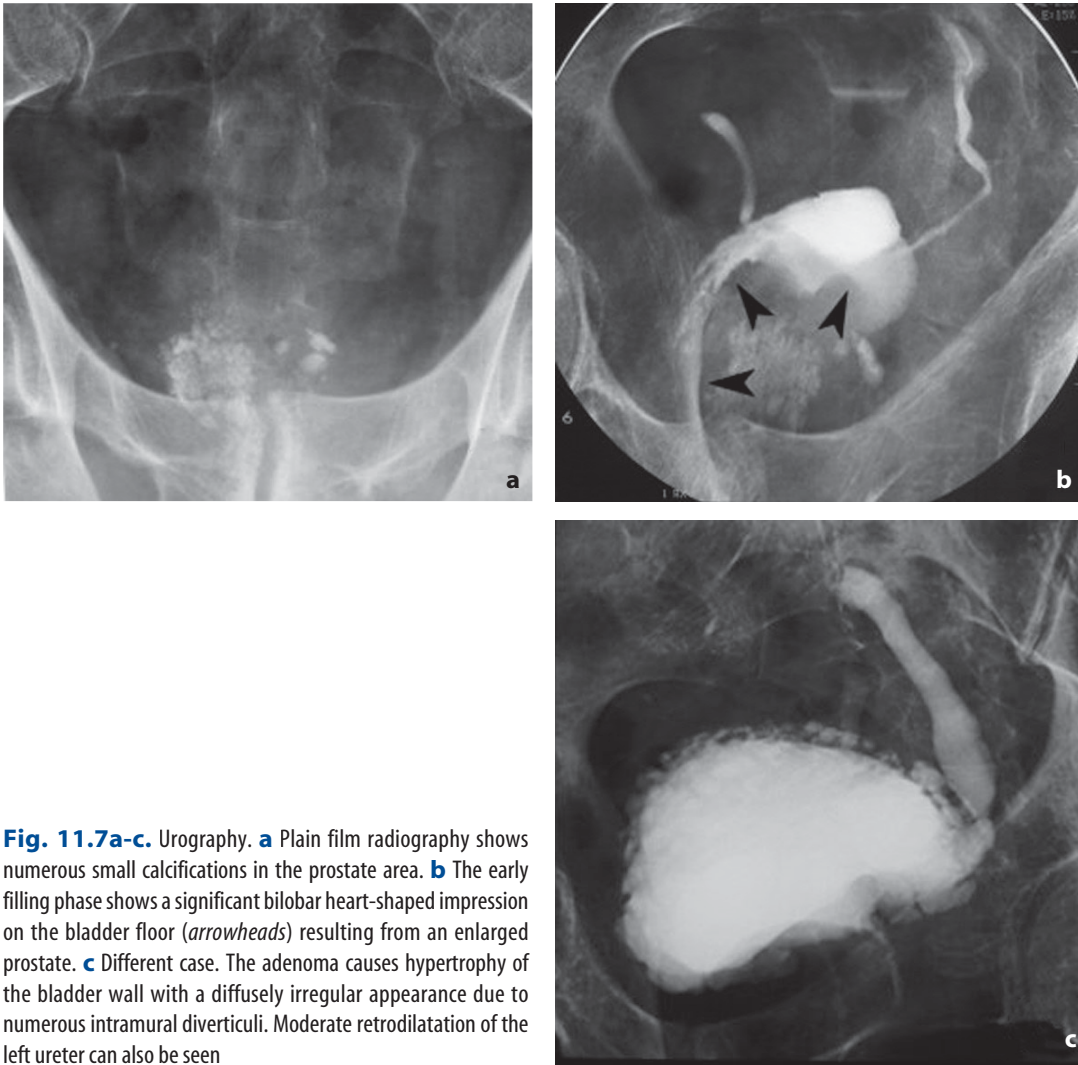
Urography. a Plain film radiography shows numerous small calcifications in the prostate area. b The early filling phase shows a significant bilobar heart-shaped impression on the bladder floor (*arrowheads*) resulting from an enlarged prostate. c Different case. The adenoma causes hypertrophy of the bladder wall with a diffusely irregular appearance due to numerous intramural diverticuli. Moderate retrodilatation of the left ureter can also be seen
